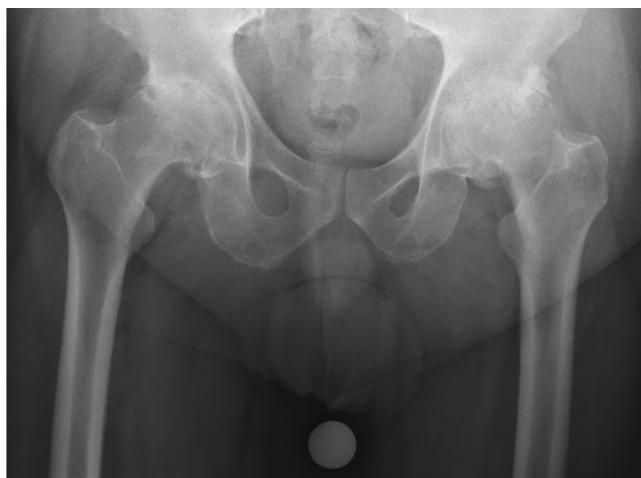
Sixty-six-year-old male with several years of bilateral knee pain. Hip radiographs revealed Grade 3 bilateral hip OA.
